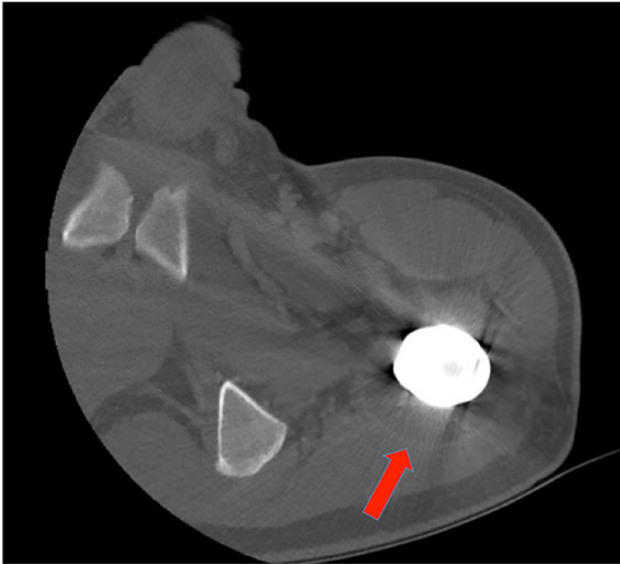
Computed tomography scan of the proximal left thigh demonstrating a 4 × 3 cm rim-enhancing collection surrounding a femoral prosthesis. Culture of this fluid grew *Bordetella holmesii*.
